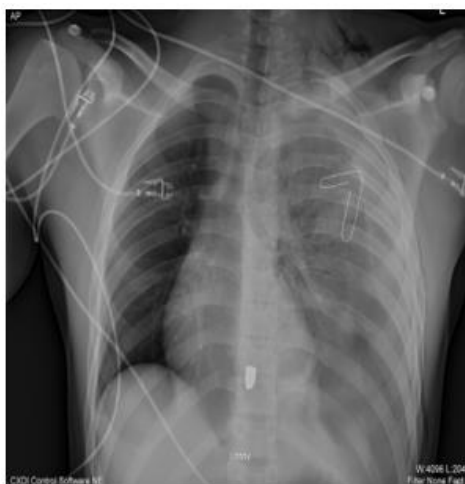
Chest radiograph prior to chest tube placement, notable for presumed entrance site at tip of paper clip, retained missile at T10, and left-sided hemothorax.
